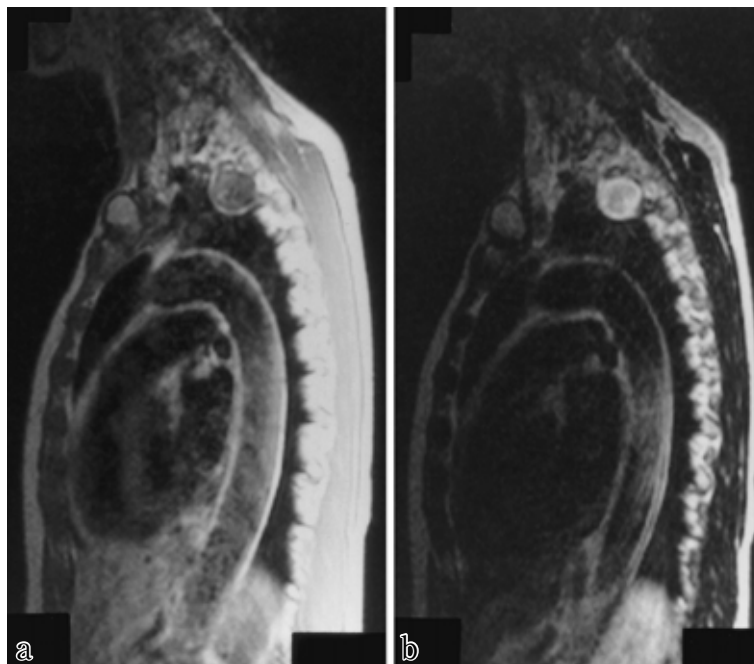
Chest magnetic resonance imaging on the digital sections indicates that the tumor is hypointense on the T1-weighted image (a) and hyperintense on the T2-weighted image (b).
